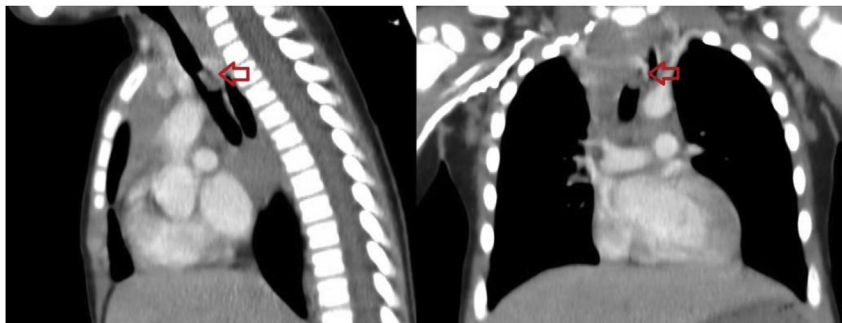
CT image. Left image is the sagittal view revealing endotracheal obstruction by the mass (arrow). Right image is the coronal view revealing mediastinal mass effect on the airway and endotracheal extension (arrow).
